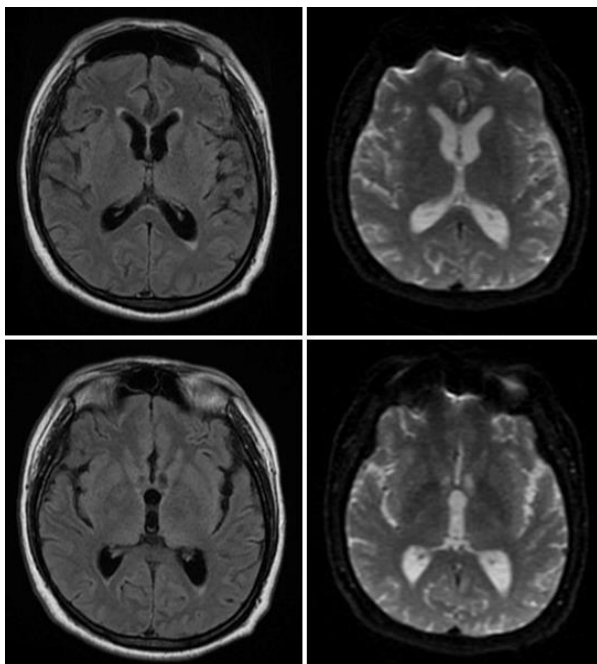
Post-TFCA MRI at the level of the lateral ventricles showing no embolic infarction or PRES-consistent changes. Left: FLAIR sequence. Right: DWI sequence.
